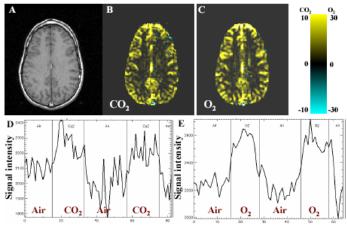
T_1 SE slice from a 27 years old volunteer obtained by 1.5T MRI. CO₂ reactivity (B) and O₂ (C) maps are given as % change of signal intensity (scale bar). Representative BOLD signal response to CO₂ (D) and O₂ (E) paradigm.
